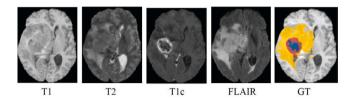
Four commonly used MRI modalities with the corresponding sub-tumor regions from the BraTS 2018 dataset. denotes edema, denotes enhancing tumor, and denotes necrotic and non-enhancing tumor.
